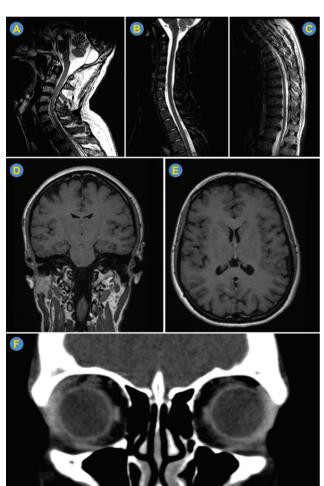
MRI after corticosteroids. Regression of the extensive spinal cord T2 hyperintensity (A, B, C, Patients 11 and 13). Regression of leptomeningeal and pachymeningeal enhancement (D, E, Patient 13). Orbital CT in Patient 3 showing reduction of right lacrimal gland enlargement (F).
